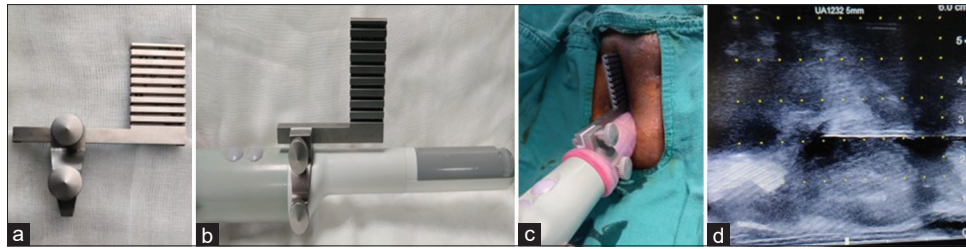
(a and b) Transperineal needle guide (UA1232, BK Medical Aps, Copenhagen, Denmark) mounted on transrectal ultrasound probe for transperineal prostate biopsy (TPB) (c) Freehand TPB (d) Position of the needle in the sagittal plane
